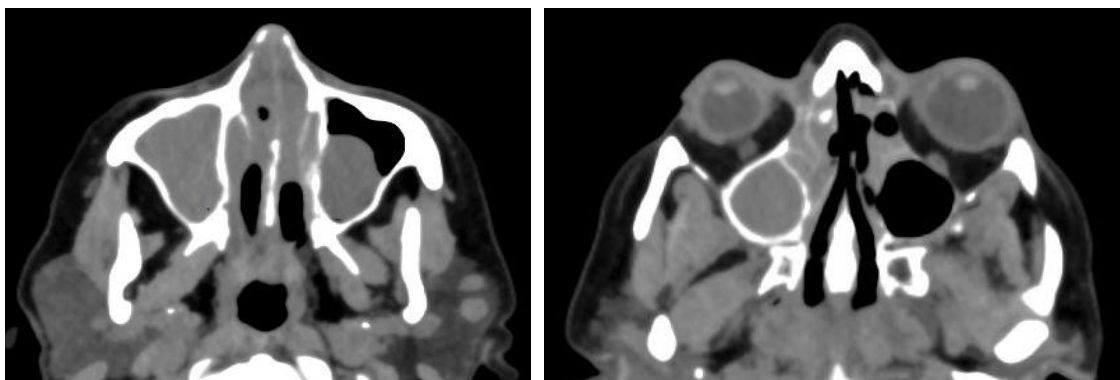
Axial section of a facial non-enhanced CT scan showing complete filling of the right maxillary sinus and polypoid filling of the left maxillary sinus extending into the nasal cavity, spontaneously isodense with some hyperdense areas.
